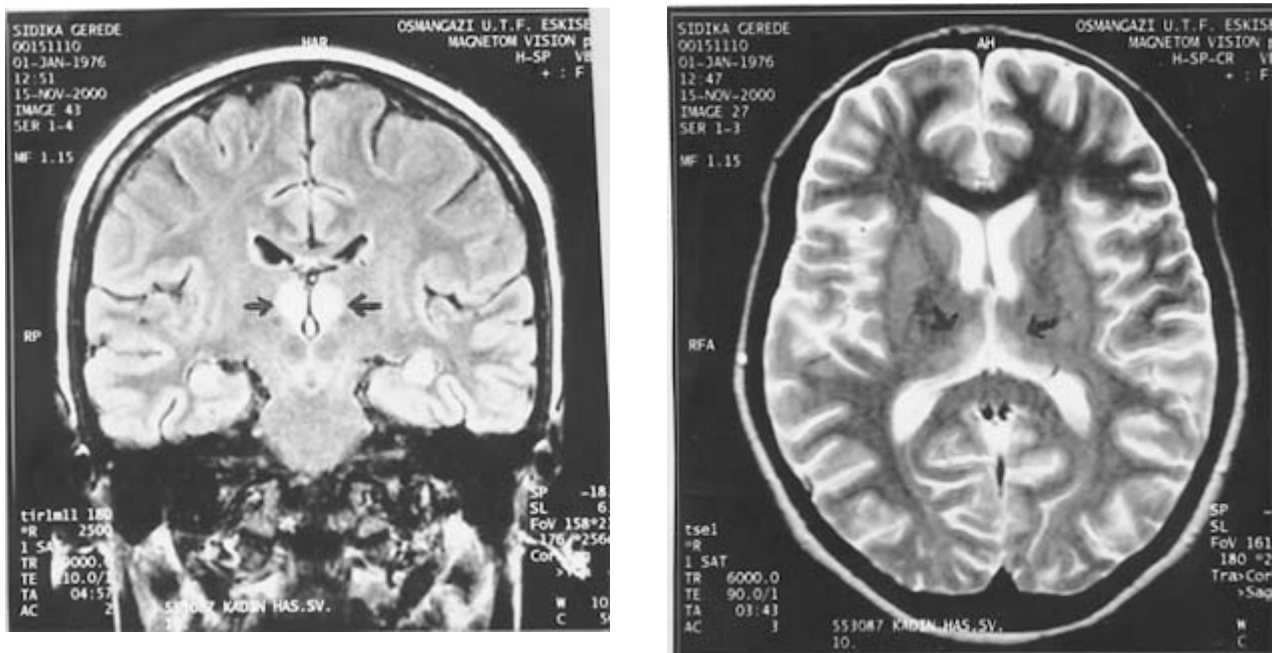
(a +b) Magnetic resonance imaging showing symmetric lesions at dorsomedial aspect of thalamic region on T₂-weighed sequences (straight arrows).
